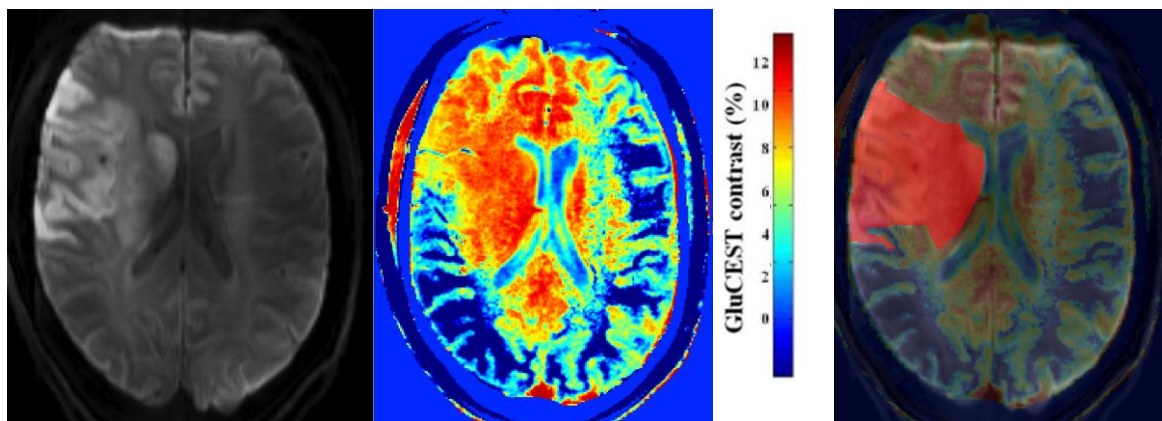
Diffusion Weighted (left) and *GluCEST* (centre) images from patient 7, demonstrating regionally increased *GluCEST* contrast in the region of infarction. On the right is a combined *GluCEST*-DWI image showing the segmented region of infarction in red.
